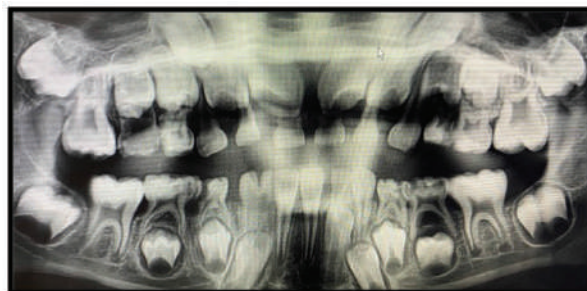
Fusion of teeth 82 and 83 was observed in the panoramic radiograph of a 6-year-old male patient.
